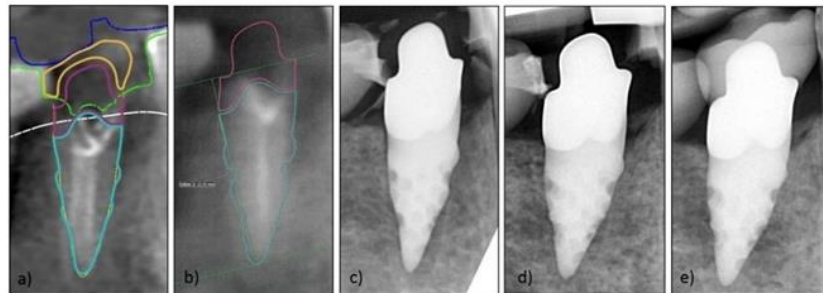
Exemplary series of X-rays for marginal bone loss (MBL) measurement: (a) visualized RAI construction by Natural Dental Implants (NDI); (b) initial image for measurement of bone loss; (c) X-ray post-implantation; (d) X-ray after healing time (before impression for loading); (e) X-ray after loading.
